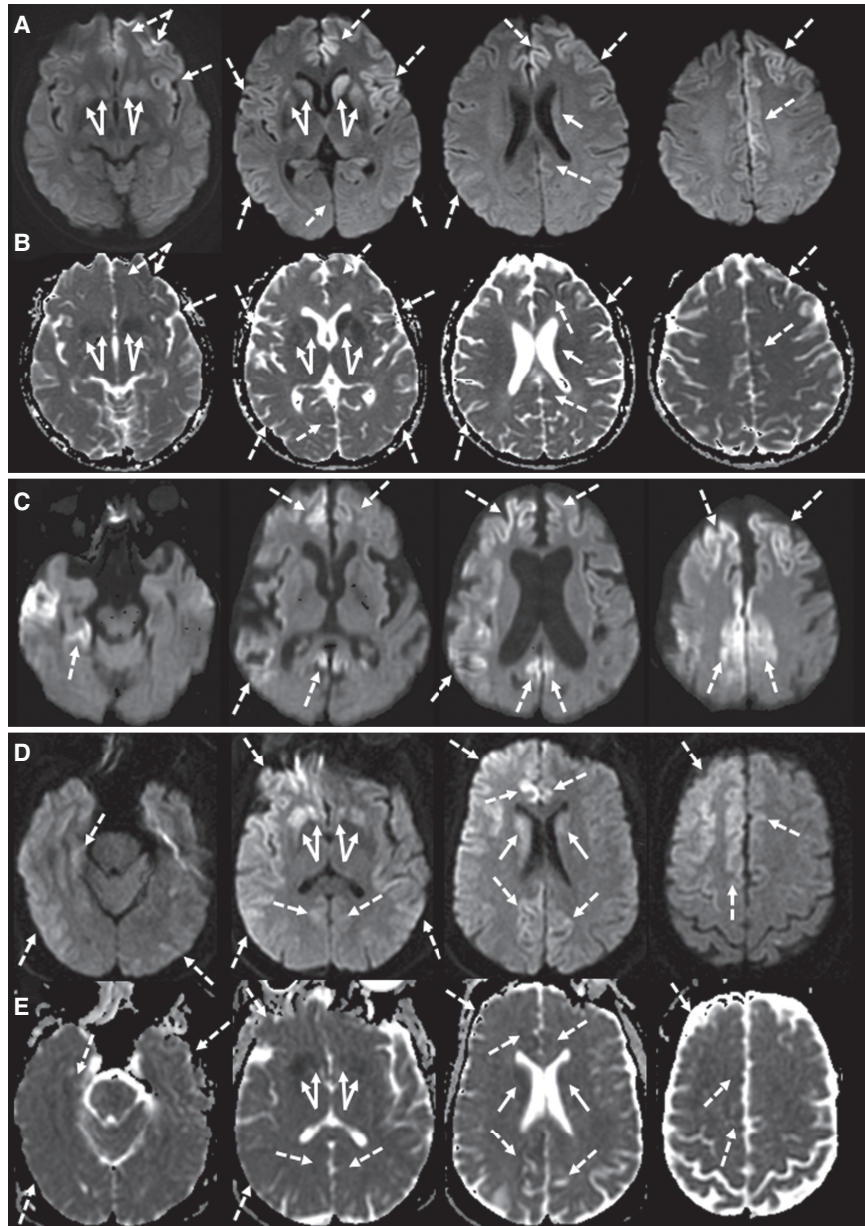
Brain magnetic resonance images (MRIs) in Fast forms of gPrD. (A) Diffusion weighted imaging (DWI) MRI of a genetic Creutzfeldt–Jakob disease (gCJD) 47-yr-old E200K patient 3 mo after onset shows diffuse cortical hyperintensity (cortical ribboning; dashed arrows) of the bilateral frontal and insula (left to right) and temporoparietal cortices. There was also DWI hyperintensity in the bilateral striata (left to right, solid arrows). (B) Attenuation diffusion coefficient (ADC) map of the same gCJD E200K case showed hypointensity in most of the regions that were hyperintense on DWI, confirming reduced diffusion, consistent with prion disease. (C) DWI MRI of an 85-yr-old V180I case 11 mo after onset shows diffuse cortical atrophy and cortical hyperintensity (cortical ribboning; dashed arrows) of the bilateral frontal and cingulate (right to left) and the right temporal and parietal lobes. There was no clear abnormality in the deep nuclei. (D) DWI in a 49-year-old gCJD A224V case 11 mo after the onset shows diffuse cortical ribboning (dashed arrows) greater on the right than the left and hyperintensity in the bilateral deep nuclei (solid arrows) also greater in the right. (E) The ADC map of the same gCJD A224V case showed hypointensity in most of the regions that were bright on DWI, confirming restricted diffusion, which is consistent with CJD/prion disease. Orientation is radiological (left brain is right side of figure). (Reprinted from Takada et al. 2017.)
